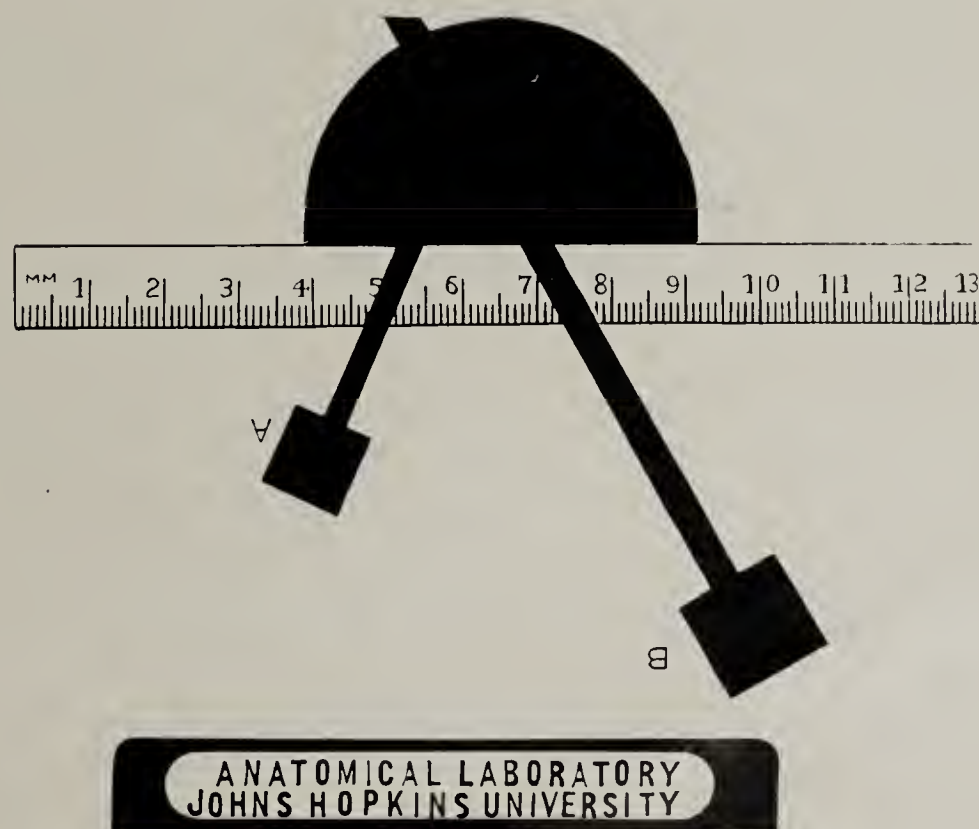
Test of instrument. Target, of medium focus, 65 cm. from X-ray plate. Steel measuring plates A, at 4 cm. and B, at 29 cm. from the plate. This target distance is the most frequently used, and the magnification of the squares is especially interesting.
